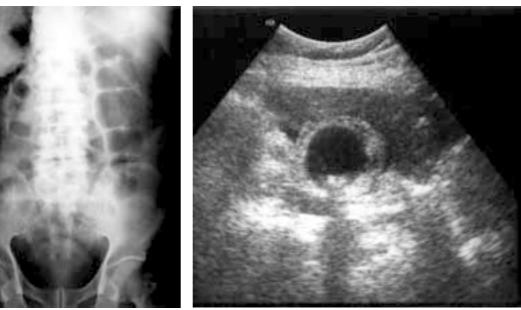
Abdominal radiograph.
